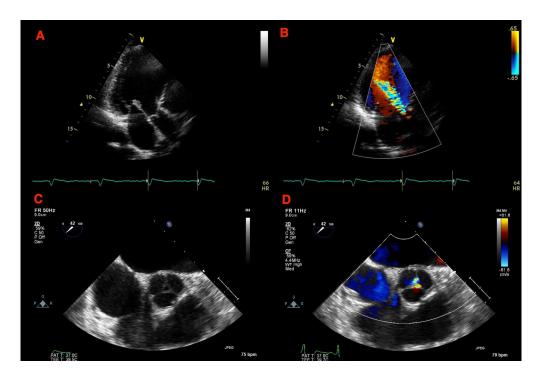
(A-B). Transthoracic echocardiogram (TTE) demonstrating severe aortic regurgitation in (A) the apical 3-chamber view showing thickening of both mitral and aortic leaflet tips with retraction of aortic leaflet tips, also seen with (B) colour flow mapping.
